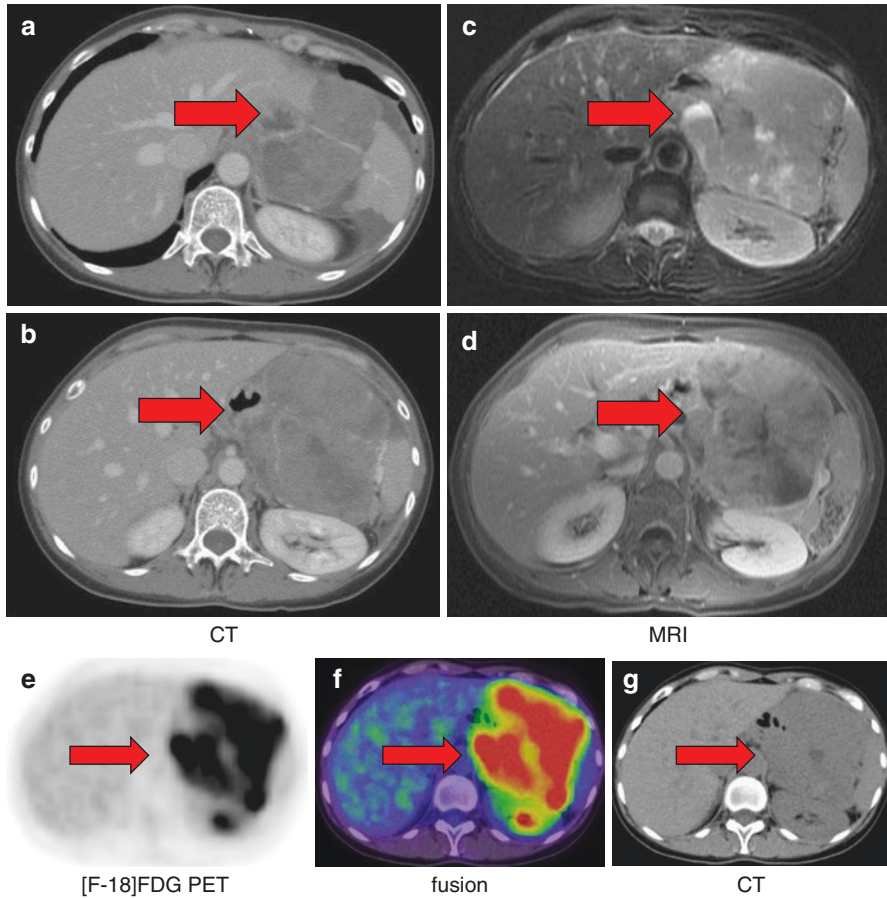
A man of 50 years with gastric GIST. Tumor greater than 11 cm in the long axis demonstrates heterogeneous enhancement on axial contrast-enhanced CT (a, b: arrow). Axial T2-weighted MR image shows heterogeneous hypersignal intensity relative to muscle (c, arrow). Tumor shows heterogeneous enhancement on gadolinium-enhanced T1-weighted MR image (d, arrow). [F-18] FDG PET/CT reveals high avidity of tumor (e-g, arrow)
